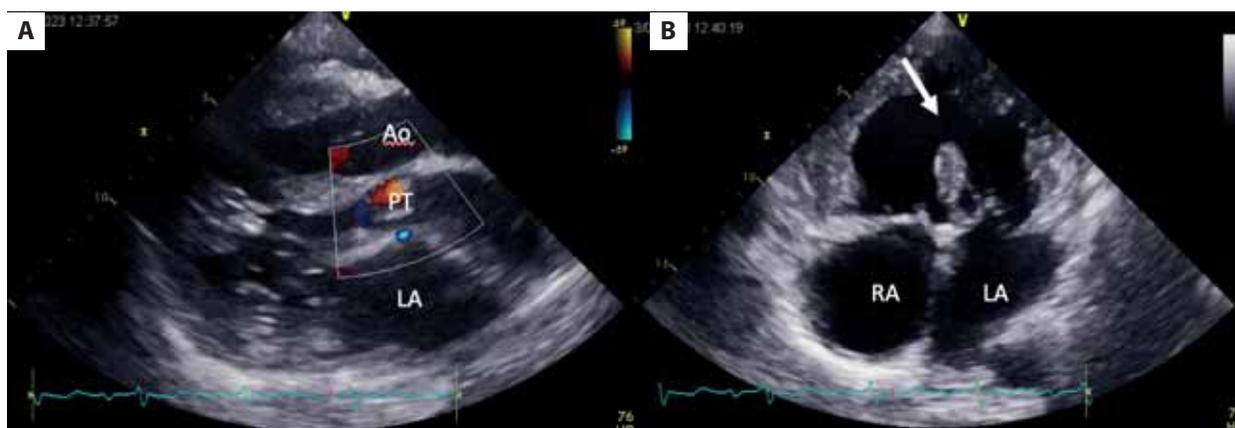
A. Echocardiography, parasternal long axis view. B. Echocardiography, four-chamber apical view; arrow indicates the ventricular septal defect
